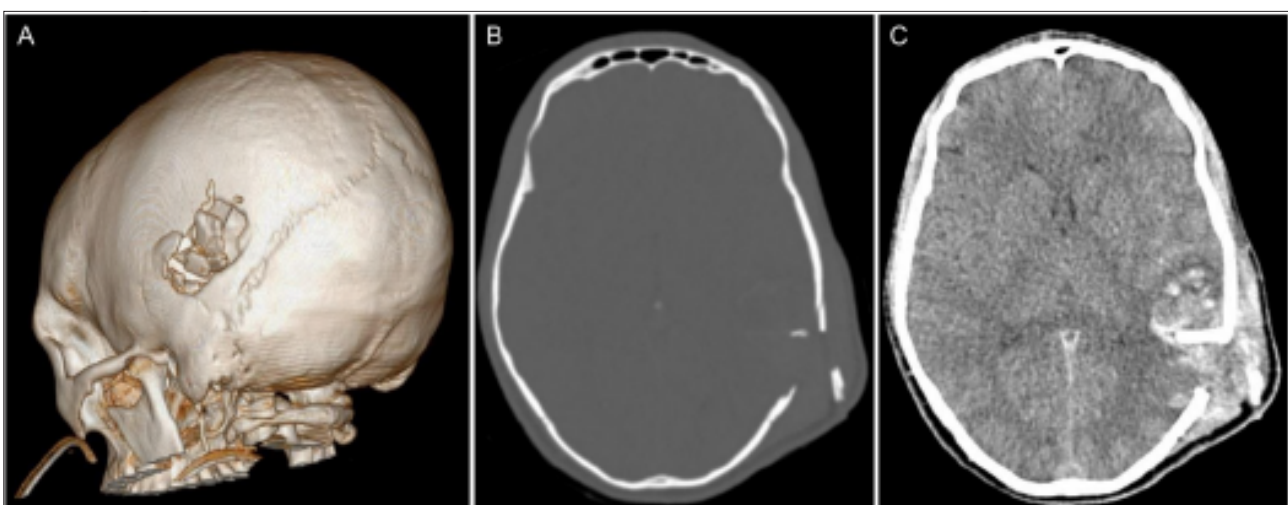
A: Three-dimensional reconstruction of a computed tomography brain (CTB) scan demonstrating a compound depressed fracture of the left parietal bone. B: Preoperative axial images (bone window) of the same patient, showing the elevated component. C: Preoperative CTB axial (soft-tissue window) showing underlying haemorrhagic contusion.
